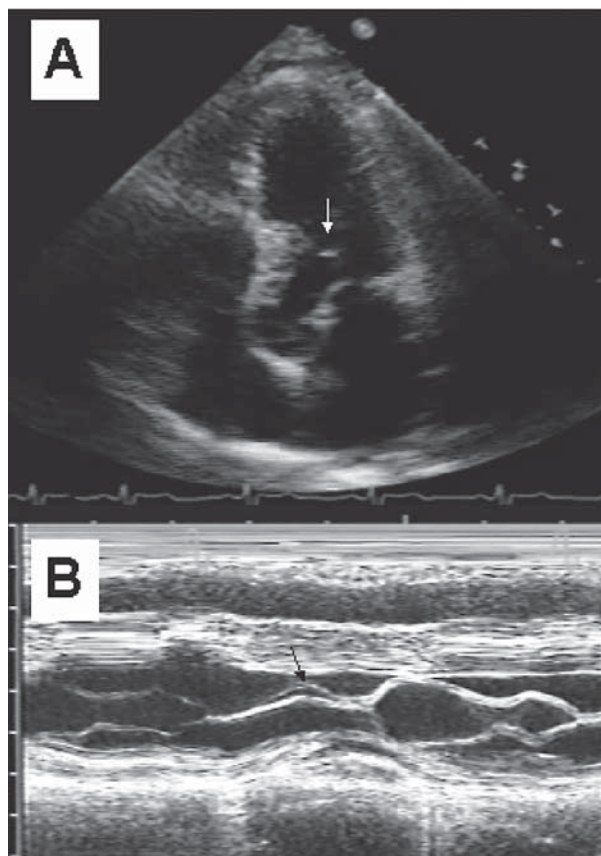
Transthoracic echocardiography of patient 2 with hypertrophic cardiomyopathy before alcohol septal ablation. A. 5-chamber view showing hypertrophied interventricular septum and systolic anterior motion (SAM) of the anterior mitral valve leaflet (white arrow); B. M-mode across the mitral valve showing SAM of the anterior mitral valve leaflet (black arrow).
